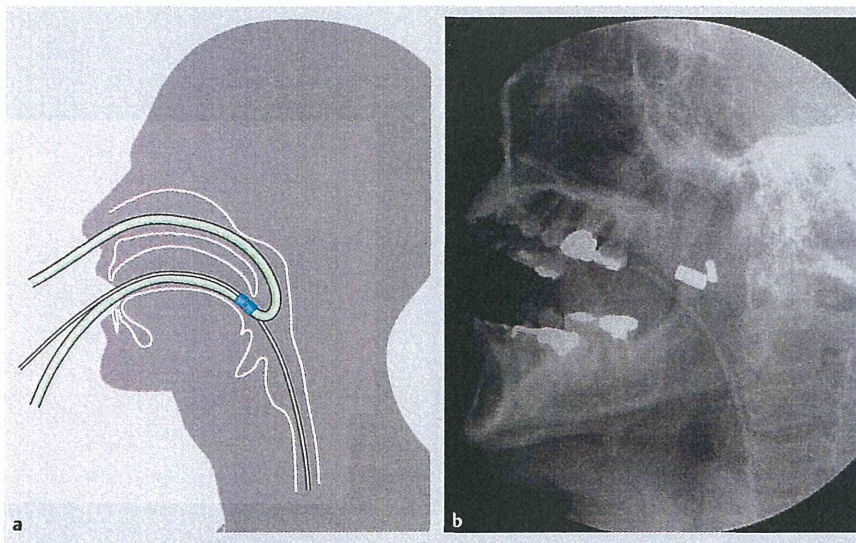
Placement of nasobiliary tube using magnet-loaded catheters. a The Nelaton tube with the “daughter” magnet has been inserted through the nostril. The suction tube with the “parent” magnet has been inserted through the mouth. The two magnets attract each other. The suction tube is led back out of the mouth with the Nelaton tube attached. b X-ray image.
